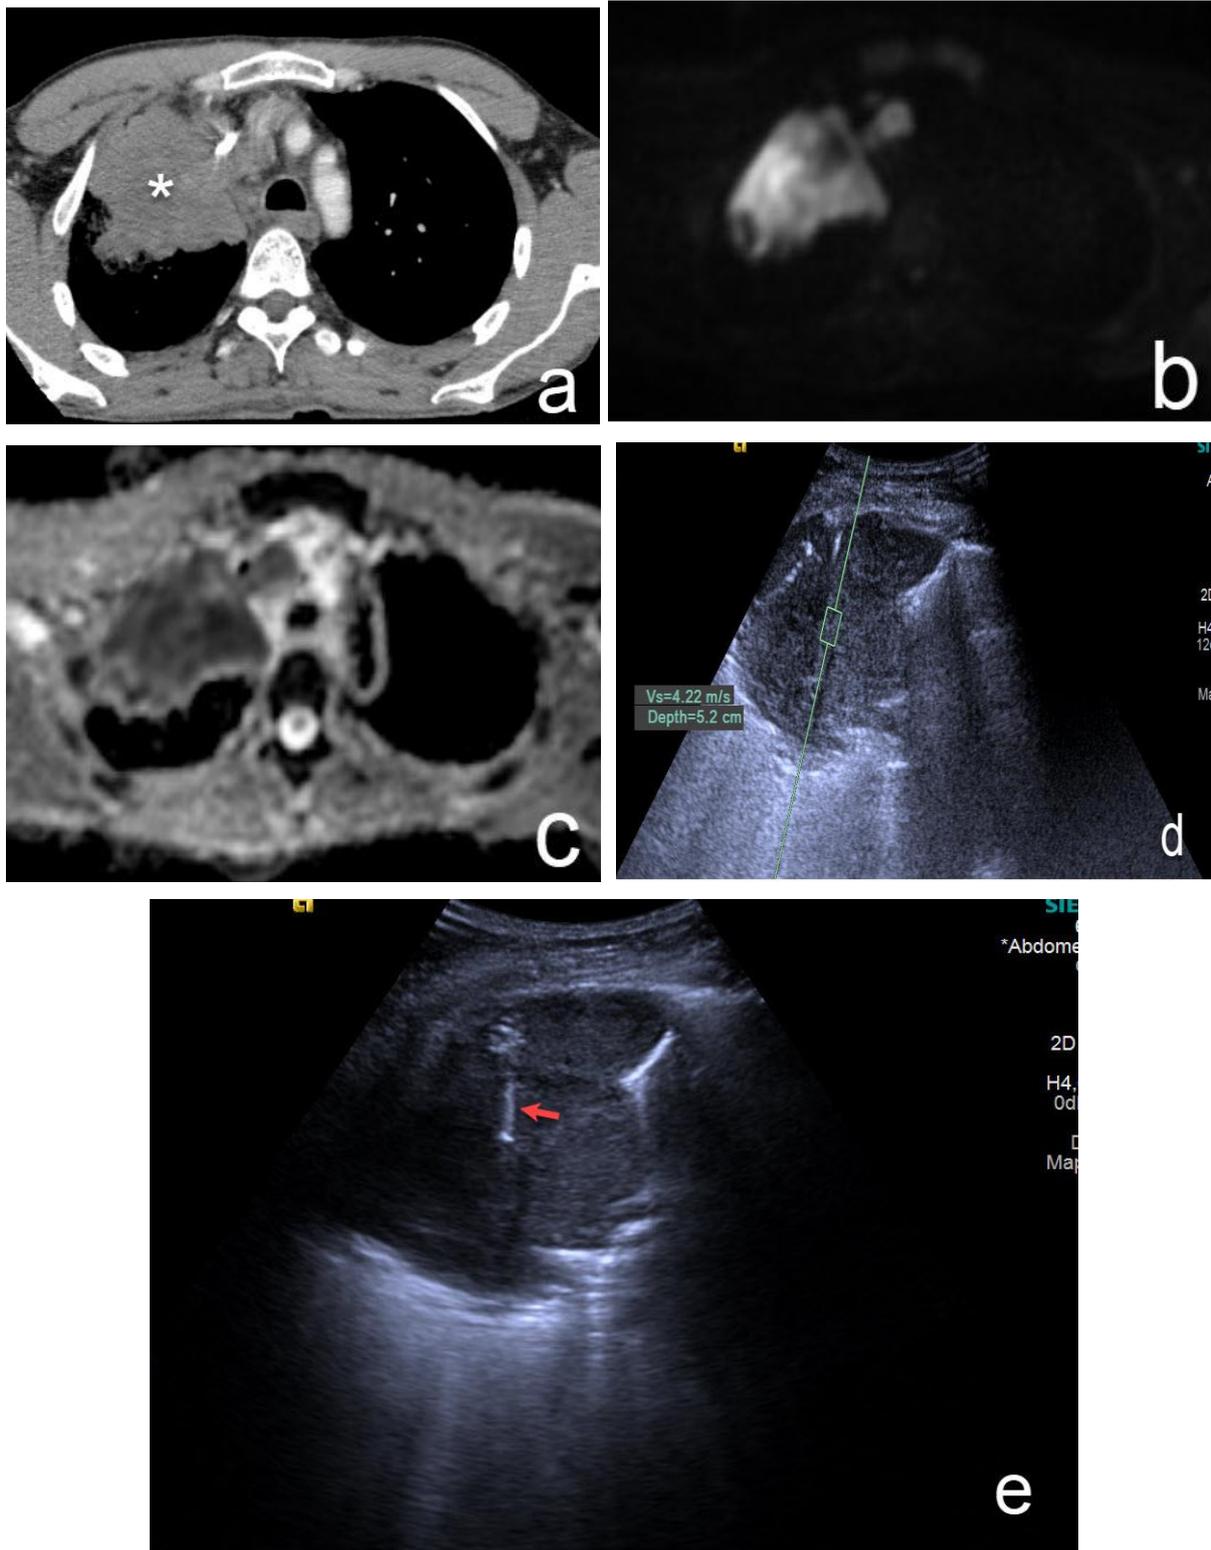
A 54-year-old smoker male with malignant right upper lobe mass (NSCLC). a. Axial CT image of the mass (asterisk). Axial DWI (b) and ADC map (c) show restricted diffusion. The mean ADC was $0.7 \times 10^{-3} \text{ mm}^2/\text{s}$ and minimum ADC was $0.46 \times 10^{-3} \text{ mm}^2/\text{s}$. The maximum SWV value of the mass is 4.22 m/s (d) and the biopsy needle (e, arrow) is shown.
